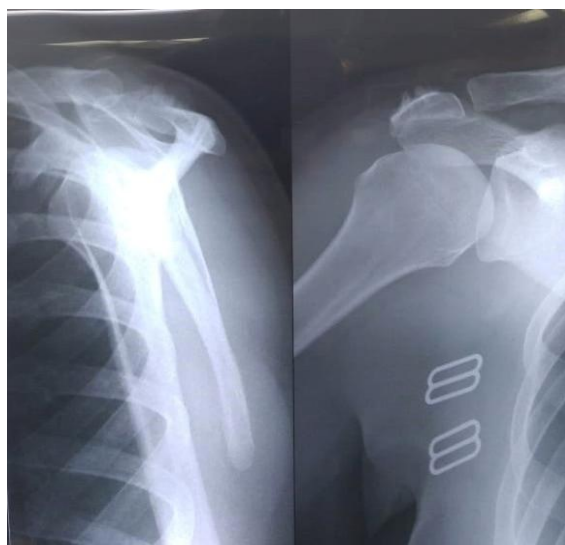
X-ray showing Os acromiale and superior spur
